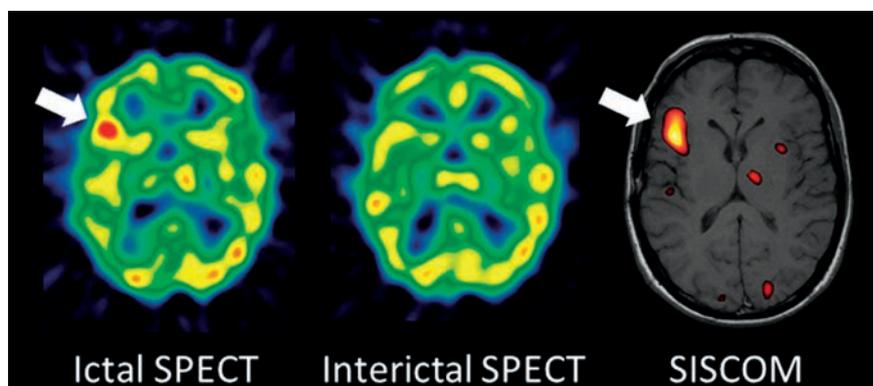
Scans in a patient with refractory focal epilepsy with an epileptogenic focus, showing increased perfusion on ictal SPECT localised to the posterior aspect of the right frontal lobe on SISCOM.
